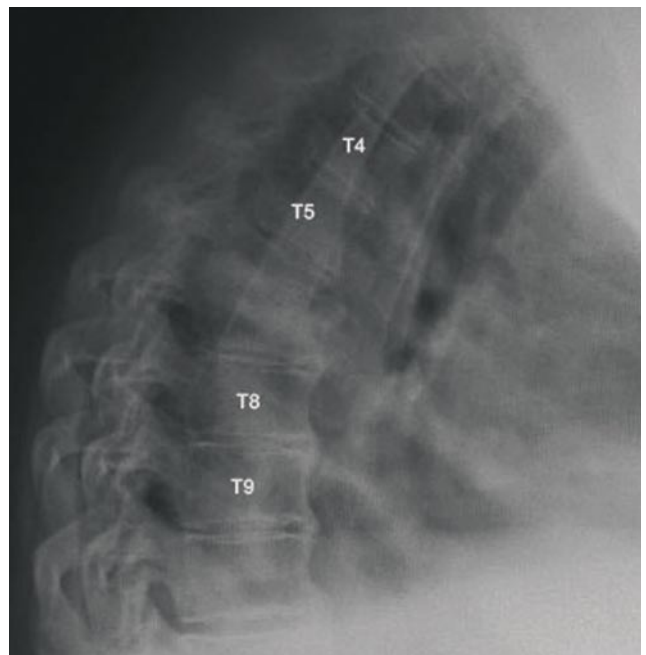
Sagittal magnetic resonance imaging of lumbar spine after gadolinium injection shows increased density of T6 and T7 endplates (white arrowheads) caused by spondylodiscitis. There is no canal compromise.
